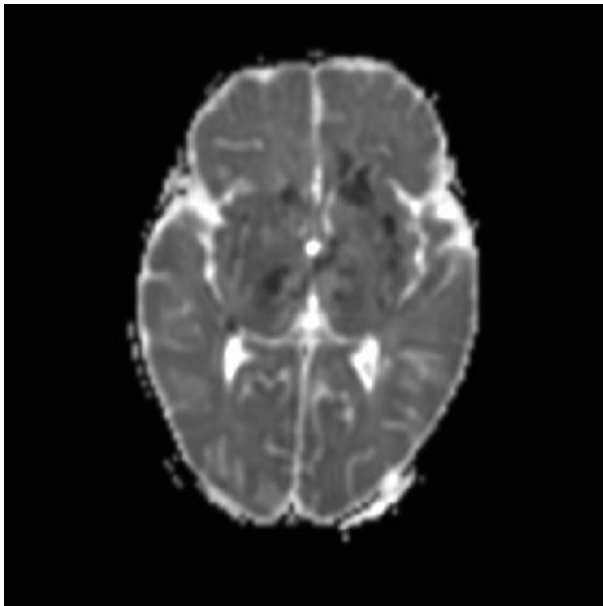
MRI IMAGING OF ACUTE NECROTIZING ENCEPHALITIS
